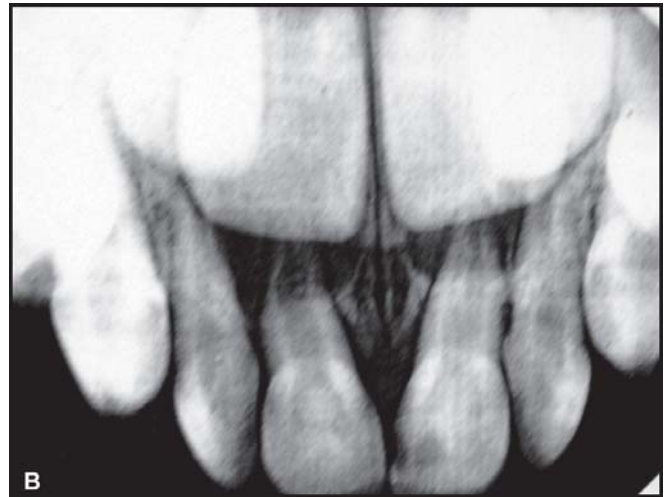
Resultant radiograph
